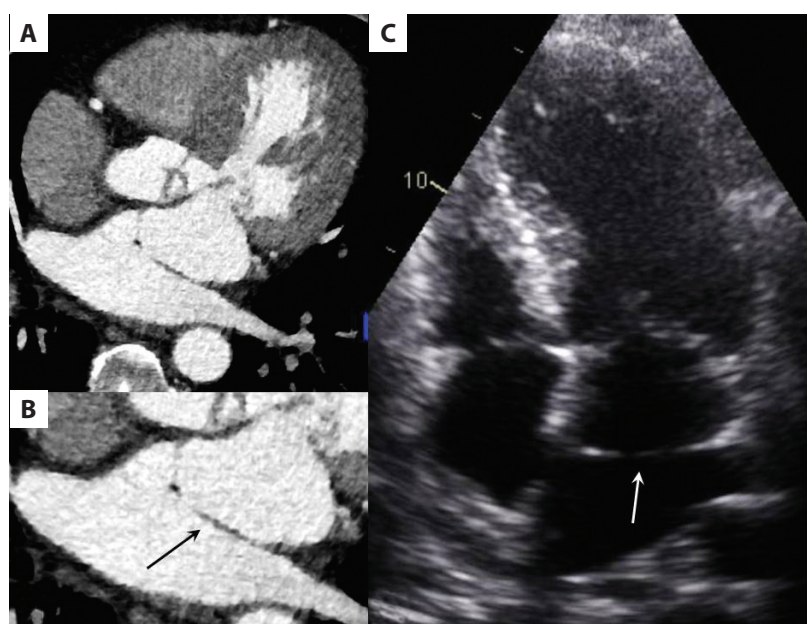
A. Computed tomography angiography. B. Magnification of the panel “A” with focus on the left atrium — white arrow indicates the fibromuscular membrane. C. Transthoracic echocardiography — apical view. The white arrow shows the linear echogenic structure across the left atrium
